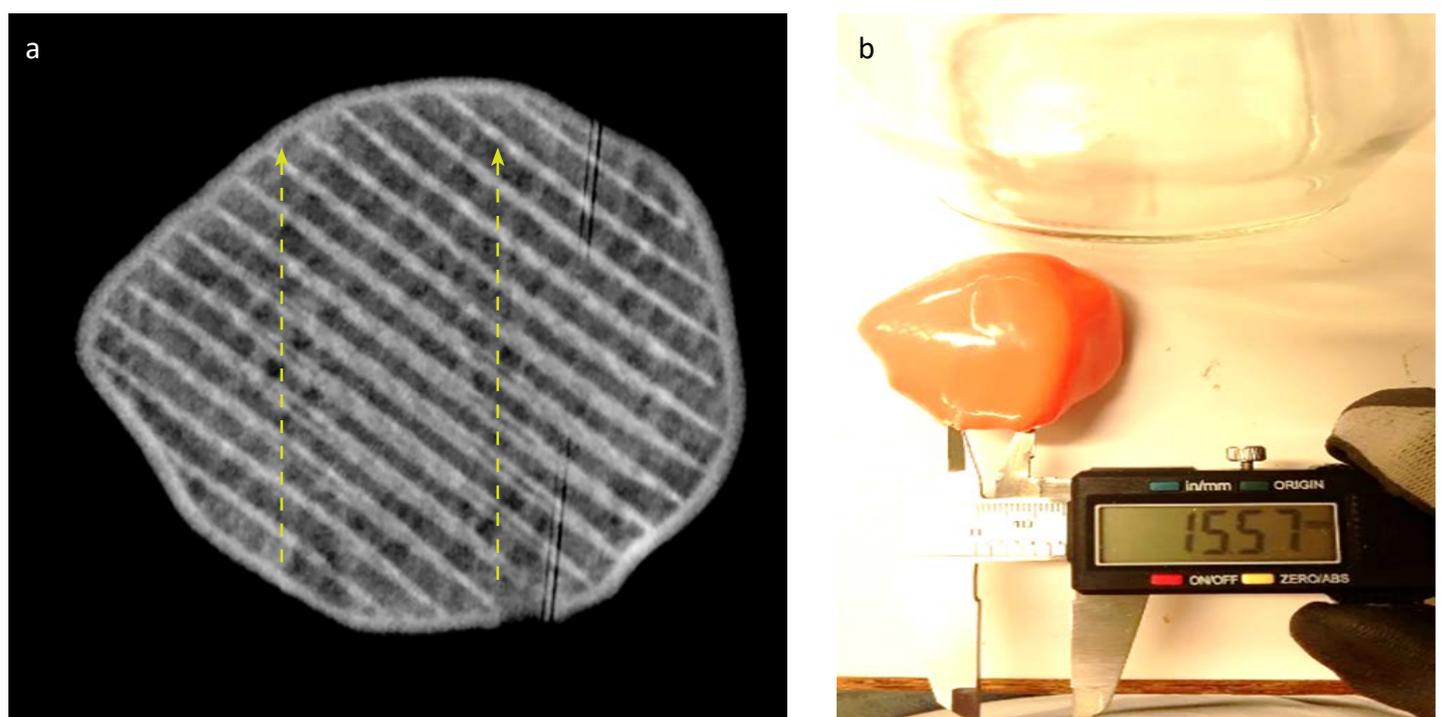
(a) X-ray images showing the parallel holes drilled into the 3D-printed patella during bench testing using the test rig. (b) The parallel holes were observed to lie at surgically acceptable distances from each other.
